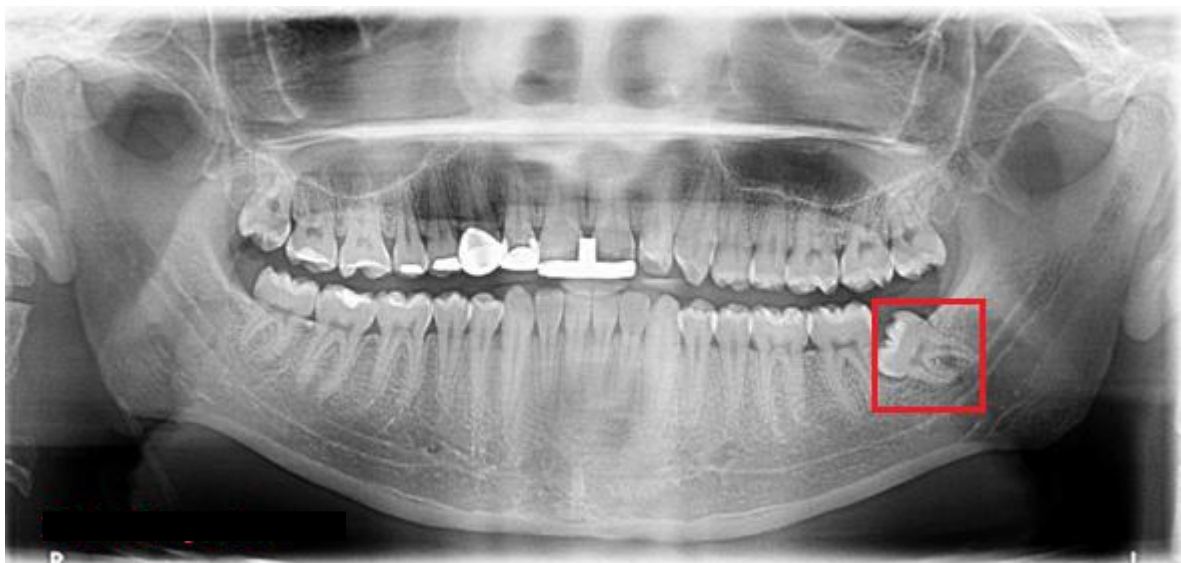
Orthopantomogram showing impacted mandibular third molar on left (Ishwarkumar, 2015)
